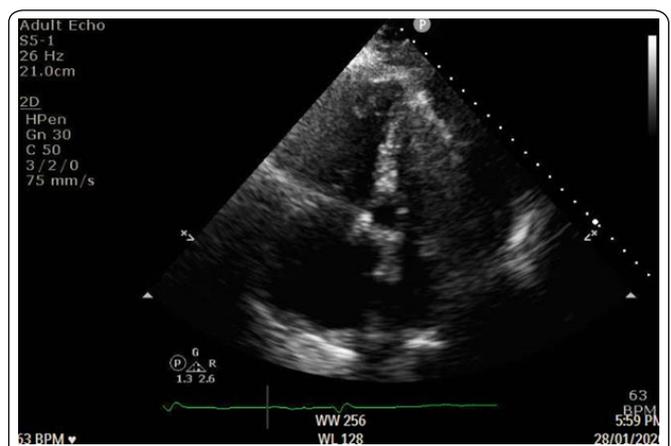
Tamponade of the LV and a severely dilated RV (apical four-chamber view).
